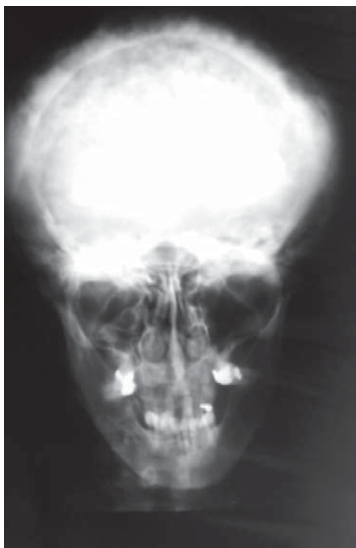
Skull X-ray showing the classical features of Paget's disease with 'cotton wool' appearance of the bone.
